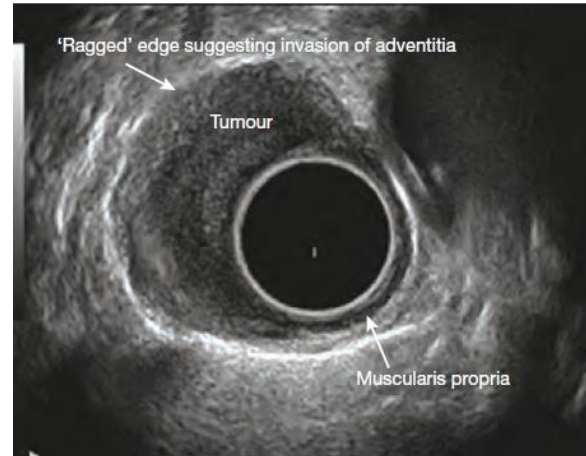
Endoscopic ultrasound image of an esophageal tumour invading into the wall.
